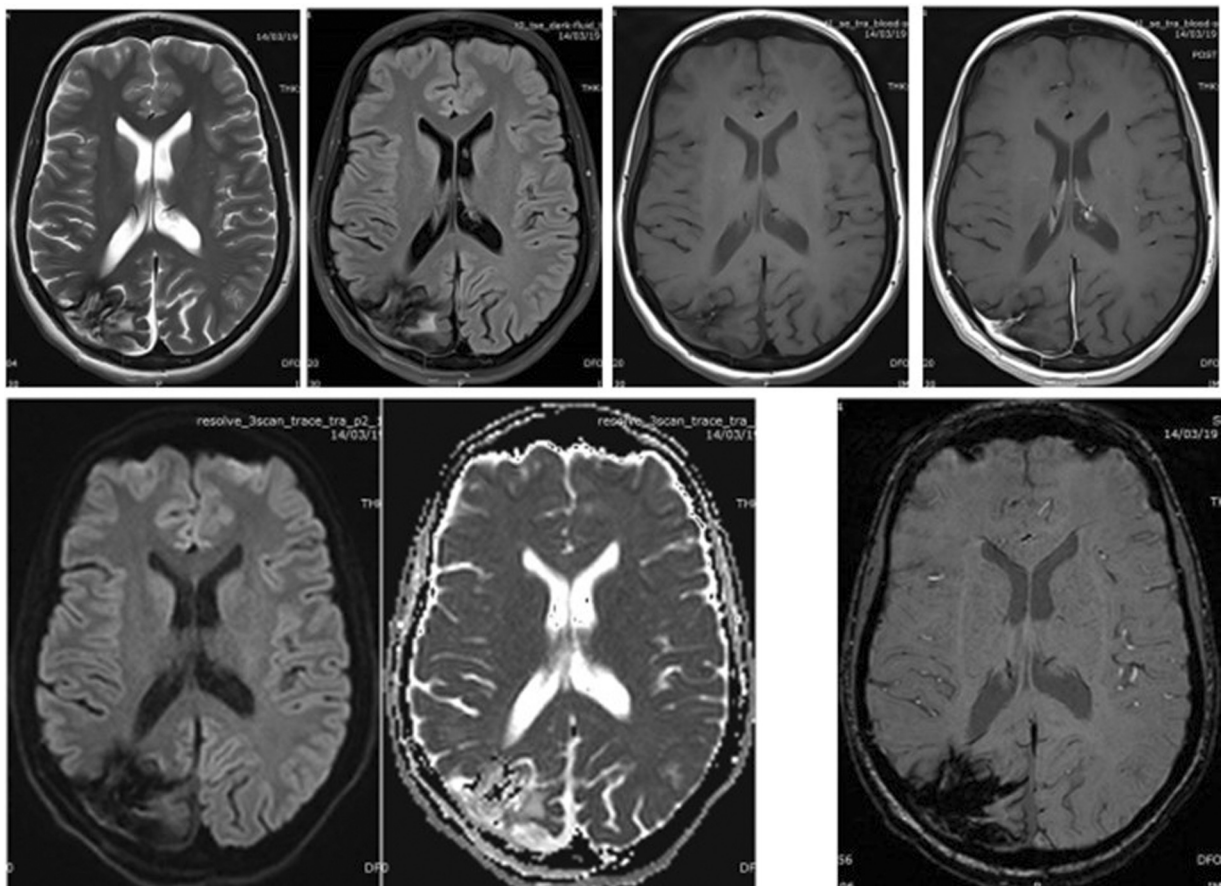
Follow-up magnetic resonance imaging scan showed total excision of the mass lesion.
